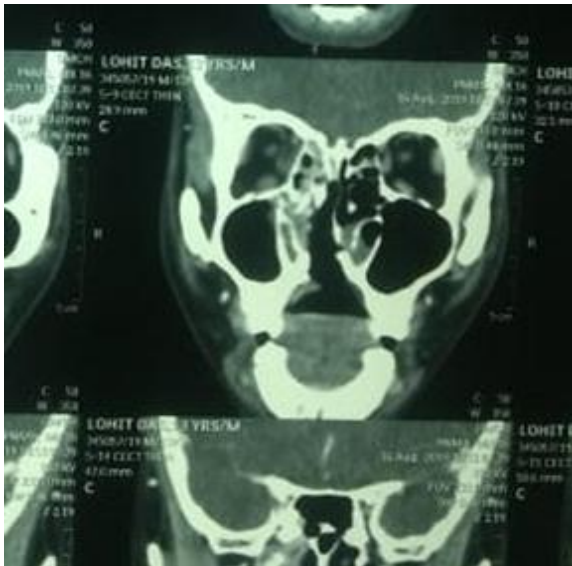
CT scan shows defect involving the hard palate with superior extension of the breach to involve turbinates, nasal septum, fracture of the ethmoid bone and lamina papyracea.
